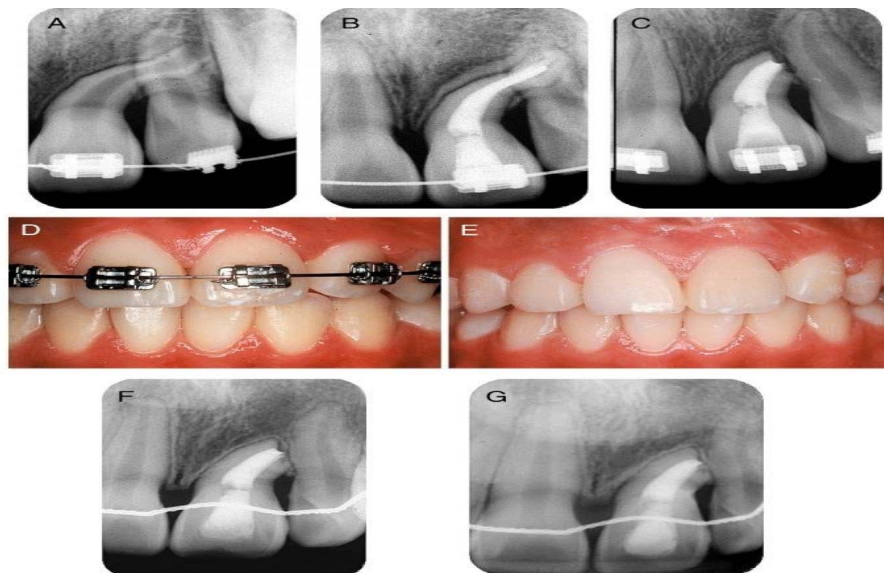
(A) Periapical radiograph of the root dilaceration; (B) after root canal filling; (C) and after apicoectomy. (D) Proper alignment of left maxillary central incisor after removal of interference and completion of torquing; and (E) final clinical aspect. (F) Follow-up after 3 years and (G) 8 years (Jose', 2010).
